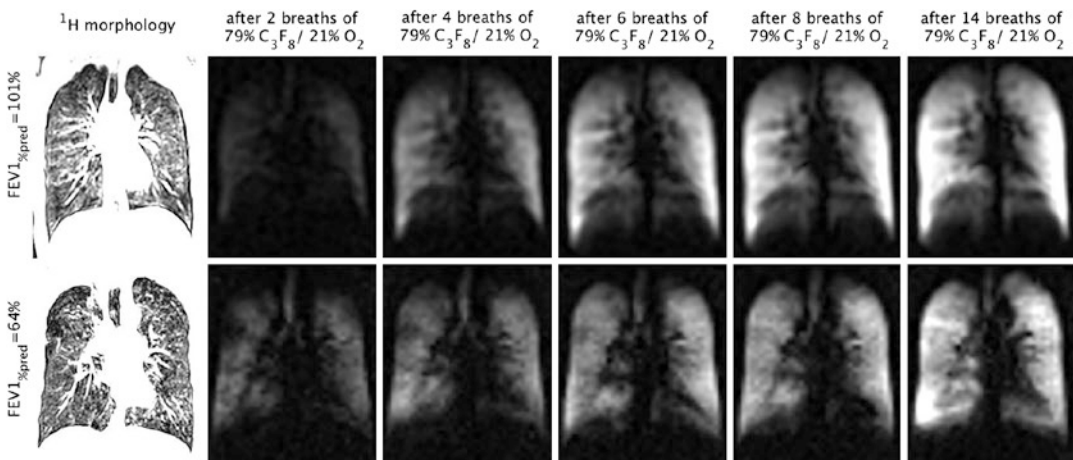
A healthy volunteer (forced expiratory volume in 1 s in % predicted ($FEV1_{\%pred}$) = 101%) (first row) and a COPD patient ($FEV1_{\%pred}$ = 64%) (second row) at 1.5 T with morphologic 1H MRI (first column) and ^{19}F gas MRI
